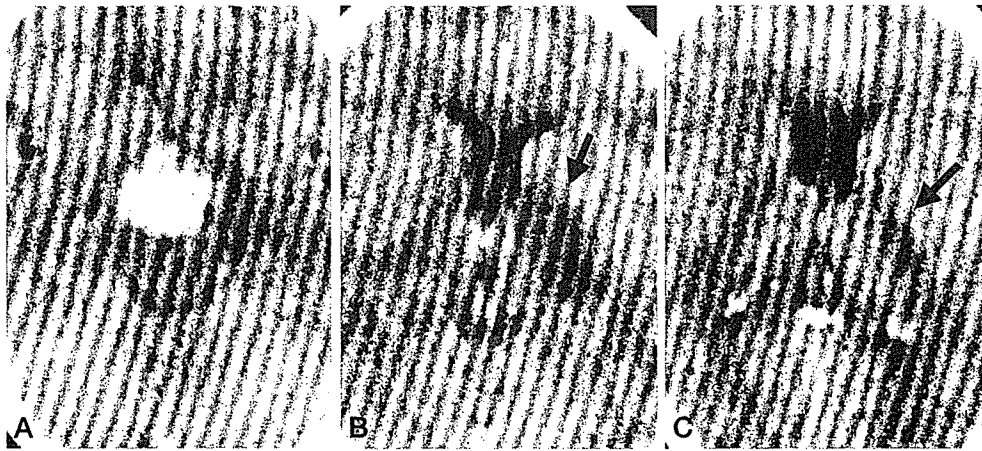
CT scans of a 33-year-old female with craniopharyngioma. A : High density lesion was seen in the pituitary region. B and C : The low density lesion was found in the brain along the internal capsule. The ischemic change was suspected along the territory of the anterior choroidal artery.
